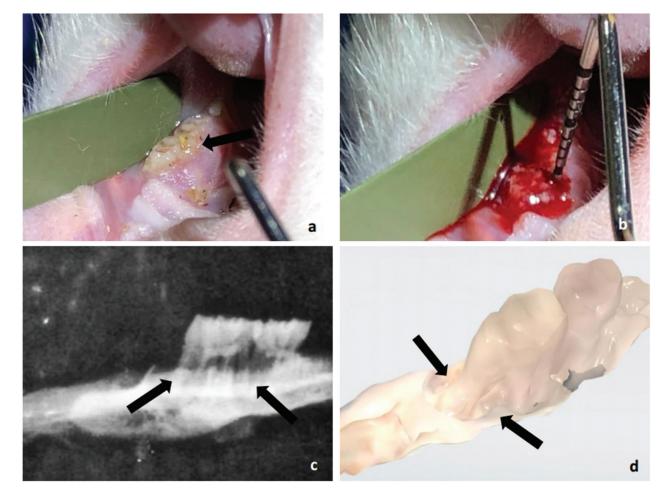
a) Biofilm accumulation on molars (arrow); b) Bleeding on probing on the first molar; c) X-ray with visible bone loss (arrows); d) 3D scan (3Shape, TRIOS 3) of bony relief with visible attachment loss and furcation involvement on first molar (arrows).
